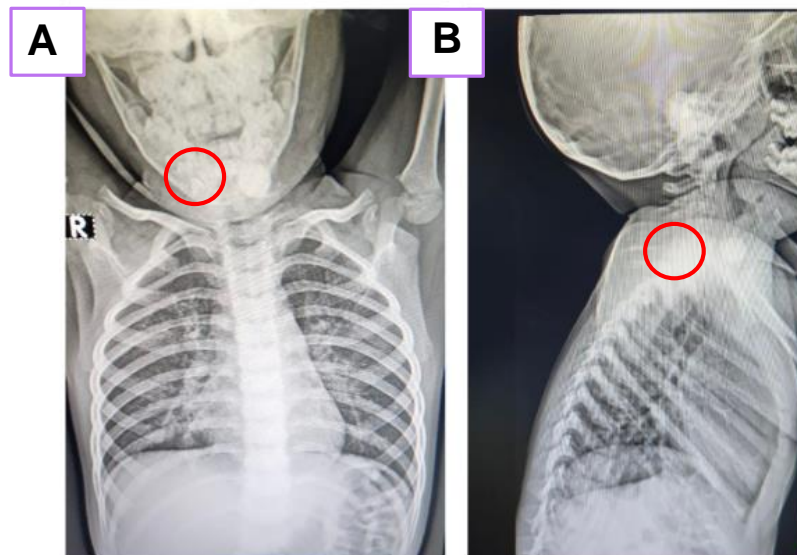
(A) Results of AP thoracic neck radiograph; (B) Results of Lateral thoracic neck radiograph when the patient arrived at the Emergency Room of Dr. Soetomo Hospital, Surabaya, November 7, 2022 at 23.37
